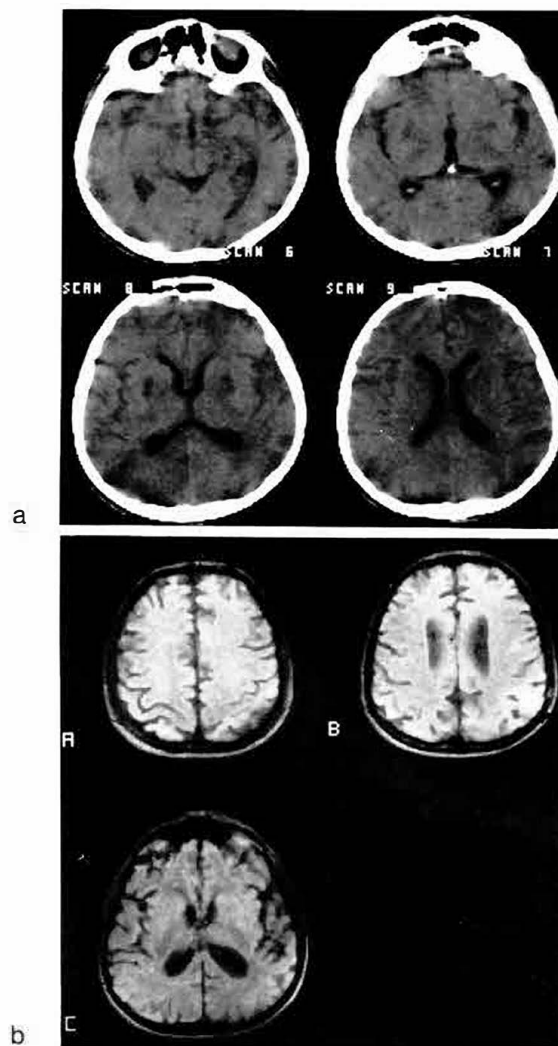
Unenhanced CT scan in a patient three months after acute carbon monoxide poisoning. There are bilateral areas of low density in the globus pallidus. Further lesions are present in the parietooccipital areas.
